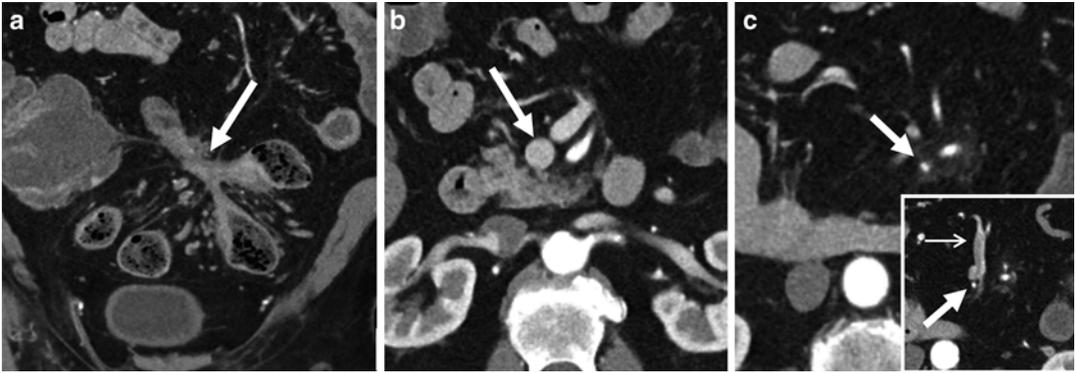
CT enterography images from anterior to posterior demonstrate complex, penetrating ileocolic Crohn's disease. Fistulas appear as extraenteric tracts with tethering of affected bowel loops (enteroenteric fistula, a—*large*
